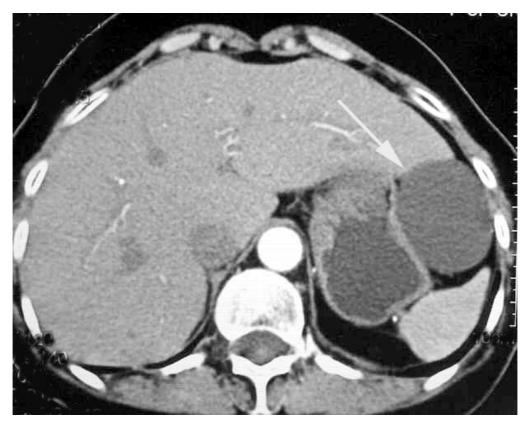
CT scan shows incidental liver cysts (arrowhead). The cyst was aspirated and the pathologic findings confirmed it to be a simple liver cyst
